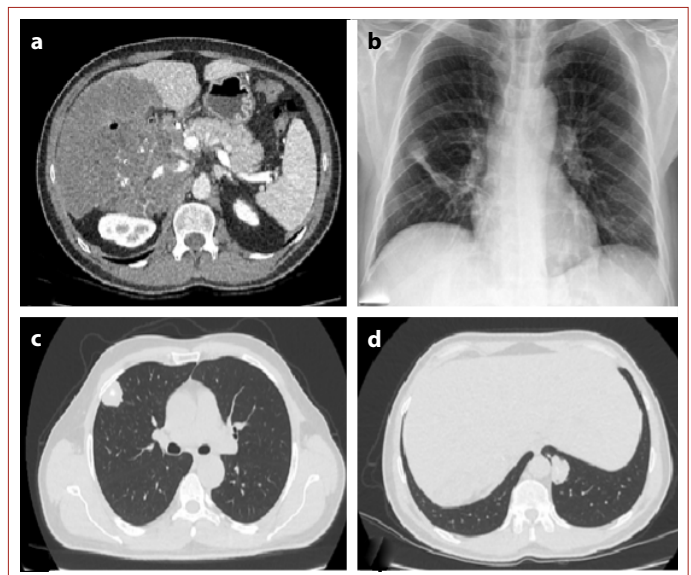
(a) Preoperative tomographic image of *Echinococcus alveolaris* in the right hepatic lobe. (b) Preoperative posteroanterior chest radiograph image of *Echinococcus alveolaris*. (c) Preoperative axial section tomographic image of *Echinococcus alveolaris* in the right lung. (d) Preoperative axial section tomographic image of *Echinococcus alveolaris* in the left lung.
